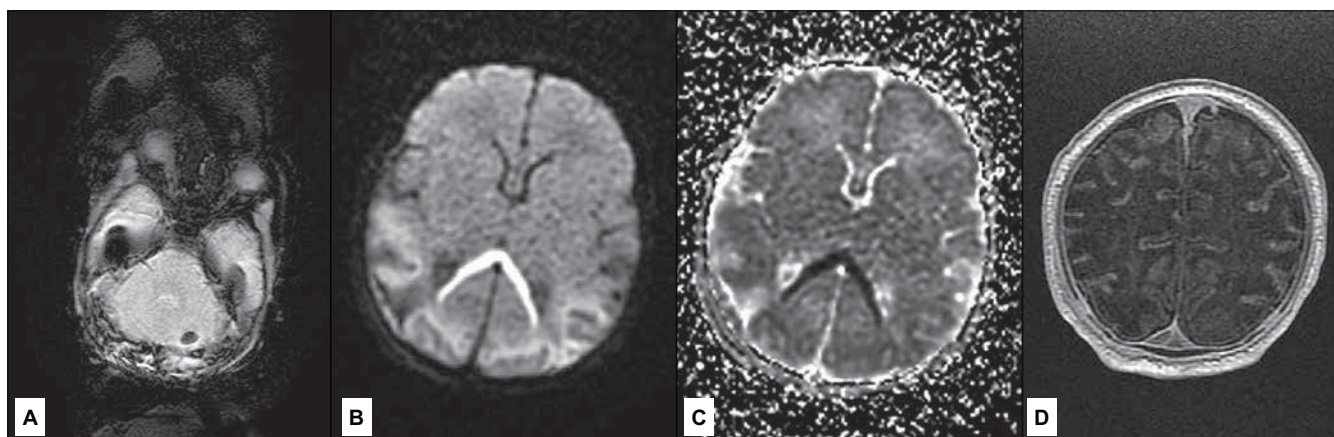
A newborn with cerebellar hemorrhage in the left hemisphere (A – SWI sequence), involvement of the corpus callosum (B – hyperintensity of the callosal splenium on DWI sequence; C – corresponding ADC map showing callosal hypointensity as confirmation of true diffusion restriction) and venous sinus thrombosis (D – FSPGR/3D/T1-weighted image after gadolinium administration – hypointense filling defect in the confluence of sinuses).
